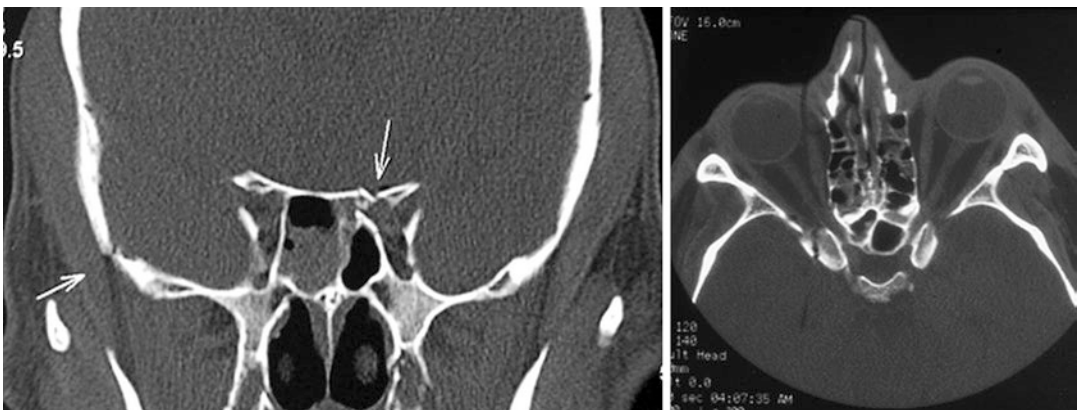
CT scans from two patients with indirect retrobulbar traumatic optic neuropathy. *Left*, patient has a fracture of the left anterior clinoid process (*long arrow*) as well as the right skull base (*short arrow*). Note that there
